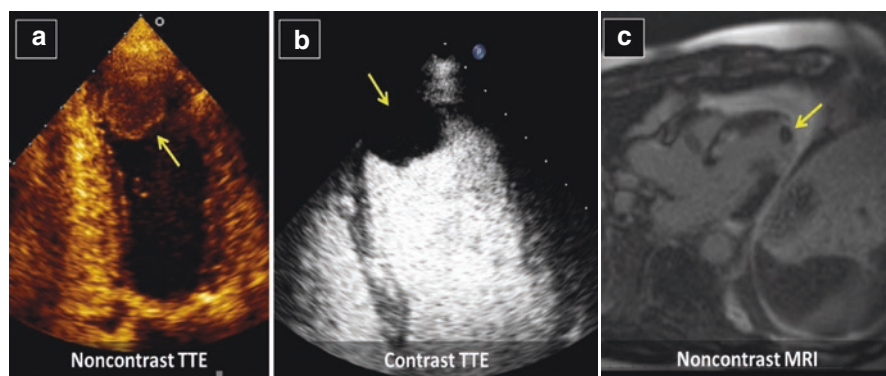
Left ventricular thrombus. (a) TTE demonstrating thrombus in the LV apex. (b) Echocardiography contrast can enhance ability to detect thrombus on TTE. (c) MRI demonstrating presence of apical LV thrombus. *TTE* Transthoracic echocardiogram, *LV* Left ventricle, *MRI* Magnetic resonance imaging
